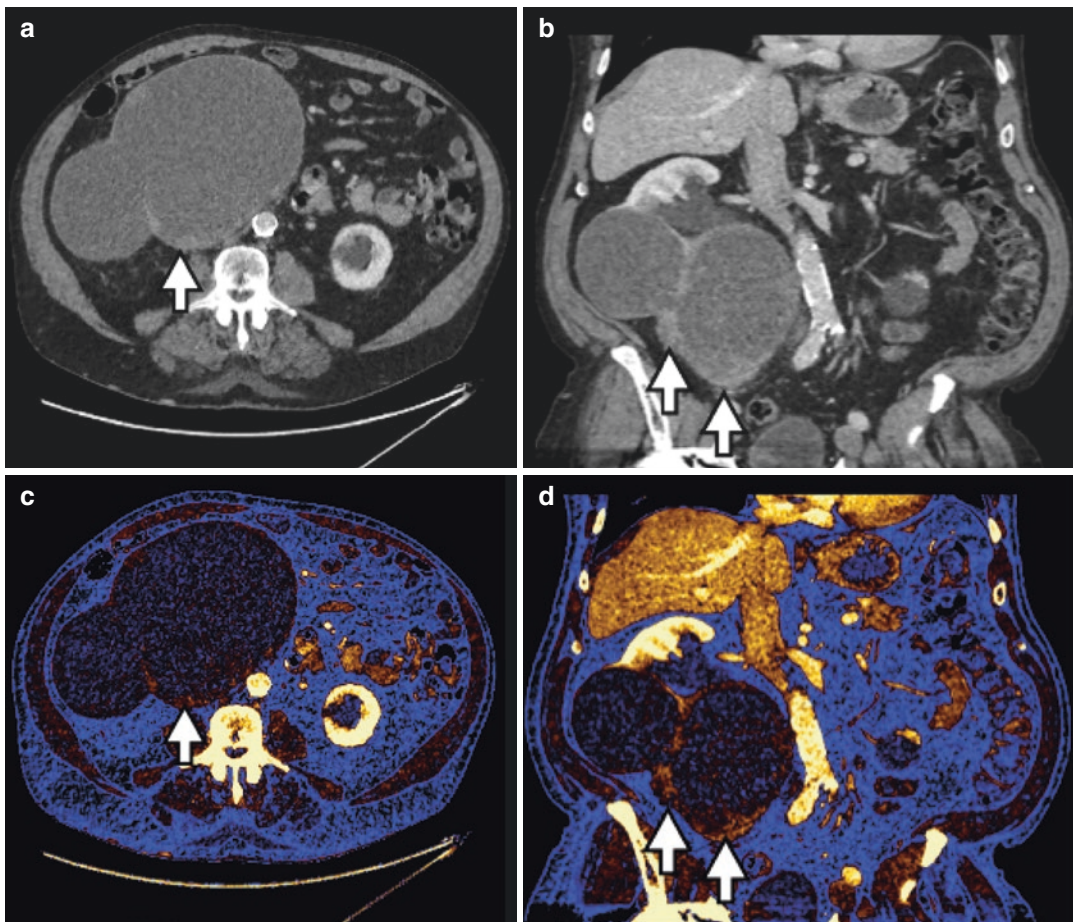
Renal cyst iodine. Contrast-enhanced CT was performed in a 64-year-old man with large complex cystic right renal mass. 70 keV axial (a) and coronal reformat (b) show high density components within the renal lesion
